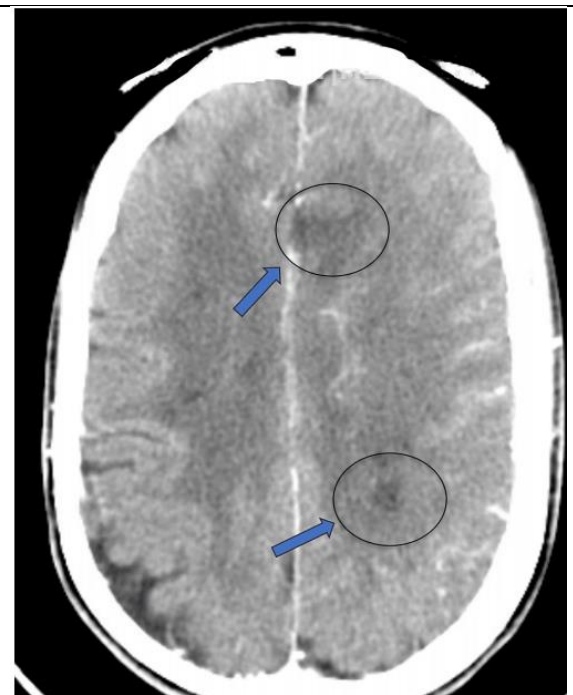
A CT scan taken 48 hours after a mechanical thrombectomy revealed the existence of further infarctions (blue arrows).
